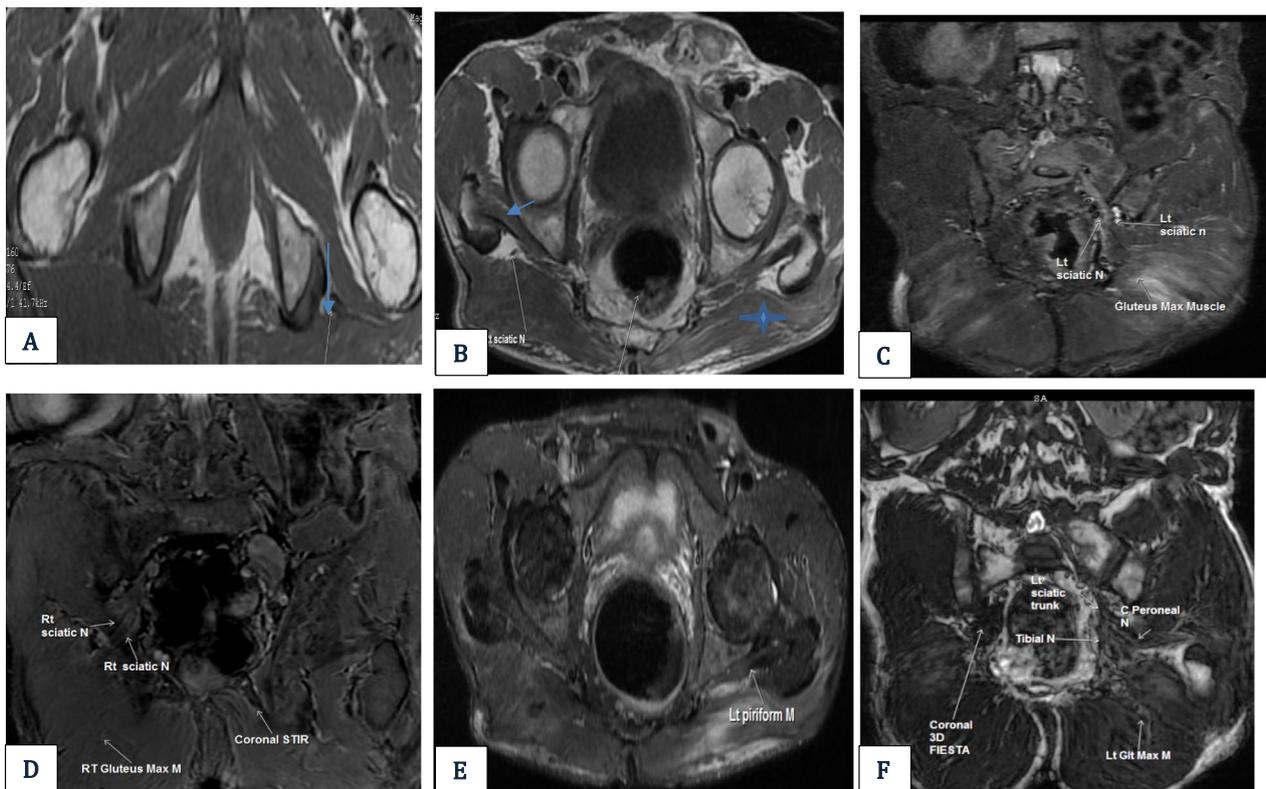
A 24-year-old female patient, having a history of intermittent left lower limb pain and cramps. Electrophysiological studies revealed prolonged F wave latency, with +ve ipsilateral straight leg raising test; MRI of the pelvis shows a relatively reduced left gluteus maximum muscle bulk (marks in B) and left sciatic nerve arrowed in (A). MRN shows high signals in the fore-mentioned muscle as well and high bifurcation of the left sciatic nerve at the upper border of left piriformis muscle with relatively increased thickness and signal intensity (C-F), denoting a left piriformis syndrome
